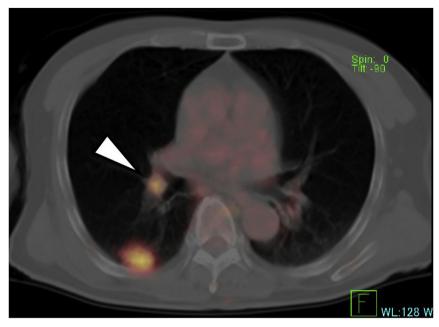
FDG-PET shows high FDG uptake in the right lower lobe (SUVmax = 6.5) and interlobar lymph node #11i, between the right middle and lower lobe bronchi (SUVmax = 2.7) (white arrowhead).
